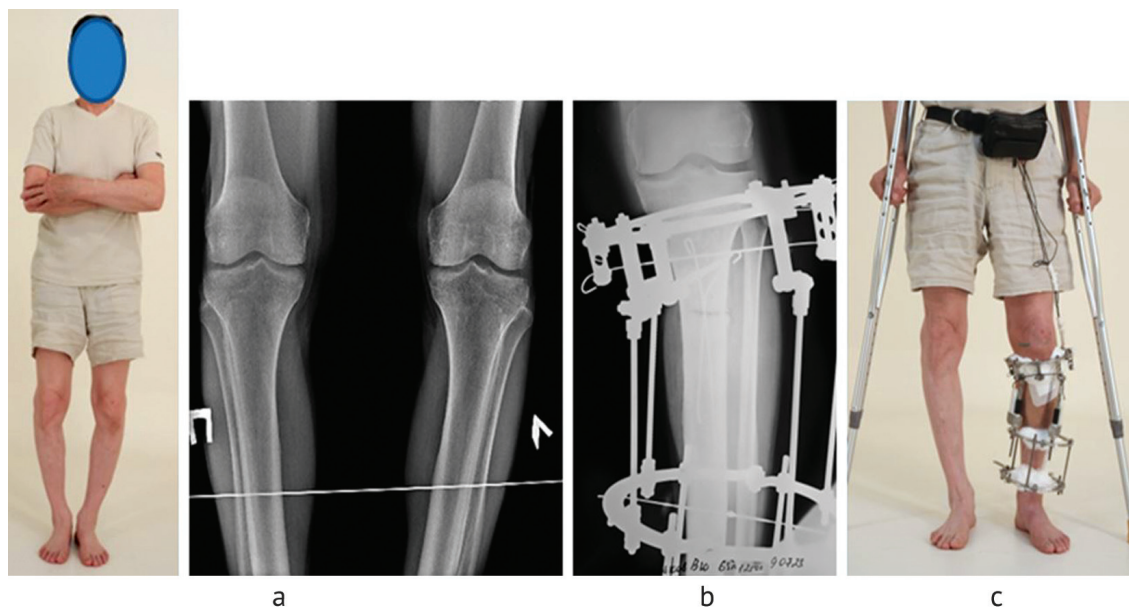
Photograph and radiographs of the patient before treatment (a); postoperative radiograph of the left tibia (b); photo of the patient during automated lengthening of the tibial bones and simultaneous correction of the deformity (c)
